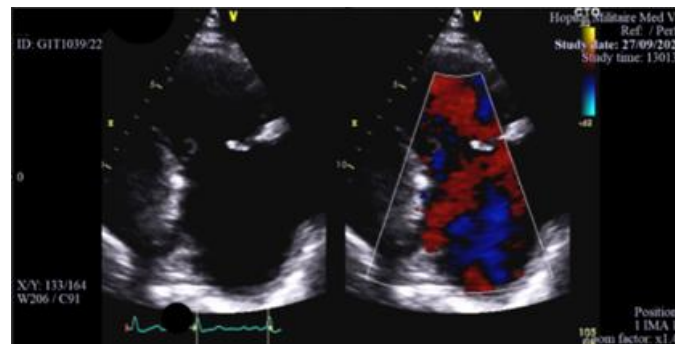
Echocardiographic images in parasternal long-axis view centered on the right cavities showing a dystrophic tricuspid valve, with a diastasis measuring 15 mm and significant regurgitation on color Doppler.
